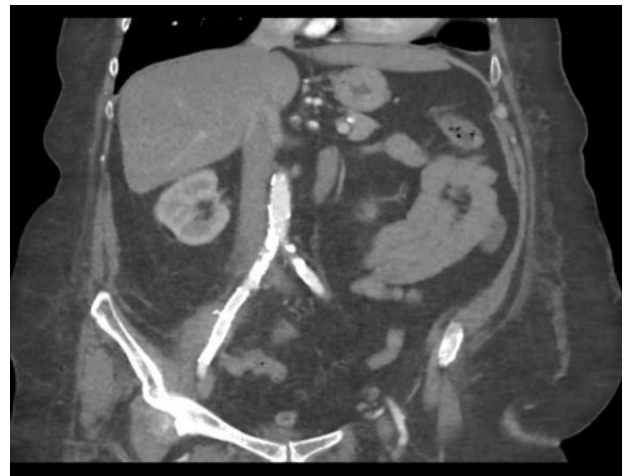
Follow up CT angio of stent *in situ*.
